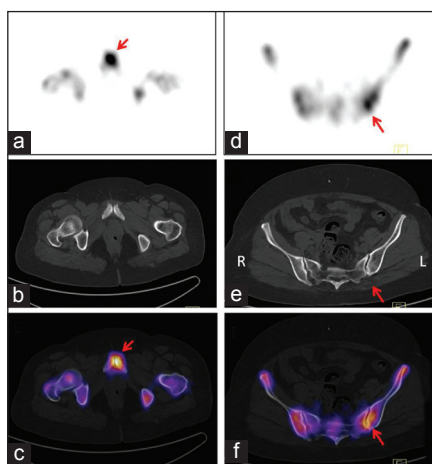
Transverse image, bone single photon emission computerized tomography (SPECT) (a), CT scan (b), and SPECT/CT scan (software based fusion) image (c), arrow shows intense tracer uptake in symphysis pubis with no structural abnormality, transverse image SPECT scan (d), CT scan (e), and SPECT/CT scan (software based fusion) image (f) shows diffuse increased uptake in left sacroiliac joint with mild sclerotic changes in corresponding area
